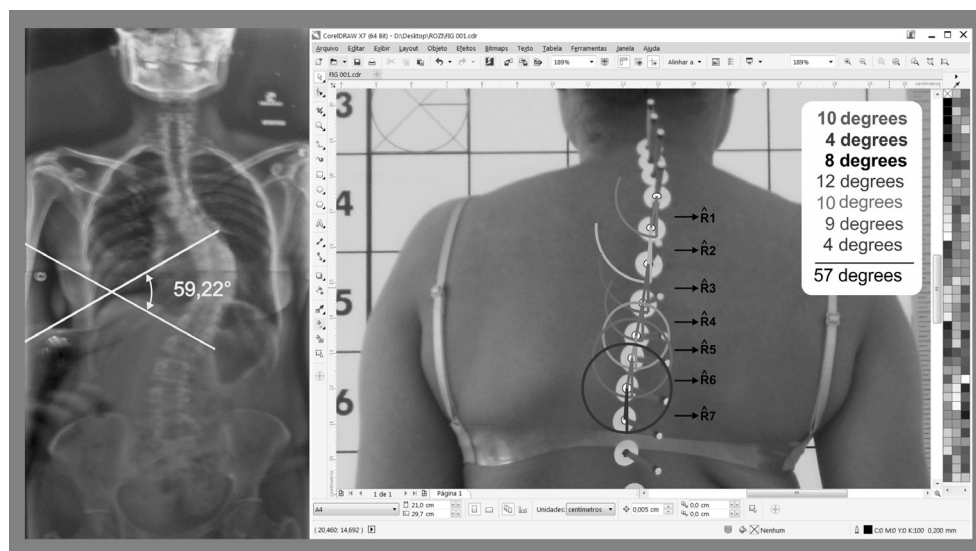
2nd phase of the photointerpretation, angular measurement, performed in the CorelDraw13® software, of a volunteer AIS carrier with left main convex thoracic curve. Measure of the angles of deviation of the spinal balance in the Y axis between the upper limit vertebrae (T4) and the apical vertebra (T10): R1 (10°), R2 (4°), R3 (8°), R4 (12°), R5 (10°), R6 (9°) and R7 (4°). On the left, measure of the Cobb angle to the X-ray of the same patient.
